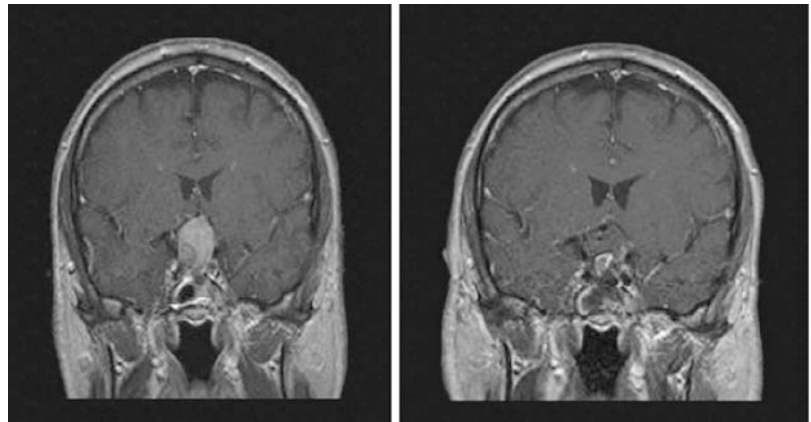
Pre- and post-operative recurrent pituitary adenoma, using the GE Signa intraoperative MRI
